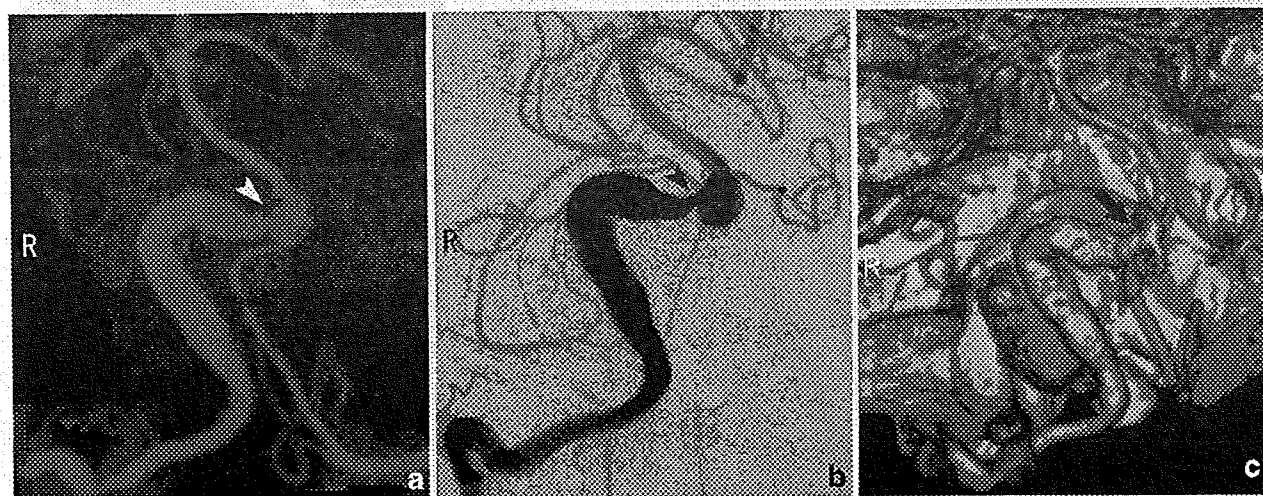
Right vertebral artery fusiform aneurysm with calcification in a 55-year-old male patient. MIP image of DE-BR-CTA (a) removed the calcification of aneurysm and revealed the distal-end
